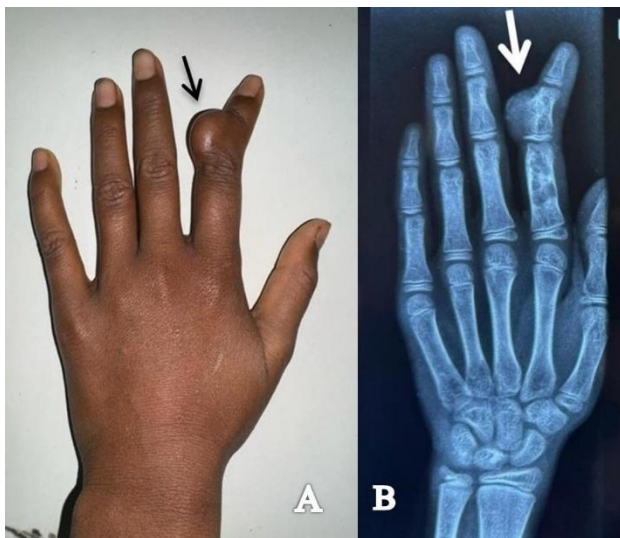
(A) clinical photograph of the left hand showing visible bony swellings over the index finger causing mild deformity and (B) preoperative radiograph demonstrating multiple expansile lytic lesions with cortical thinning and endosteal scalloping.
